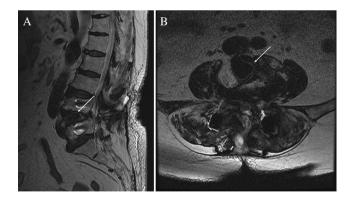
A T2-weighted MRI in sagittal (A) and axial (B) views showing a hypointense signal IVC in the intradiscal space of L4–L5 (arrow).
